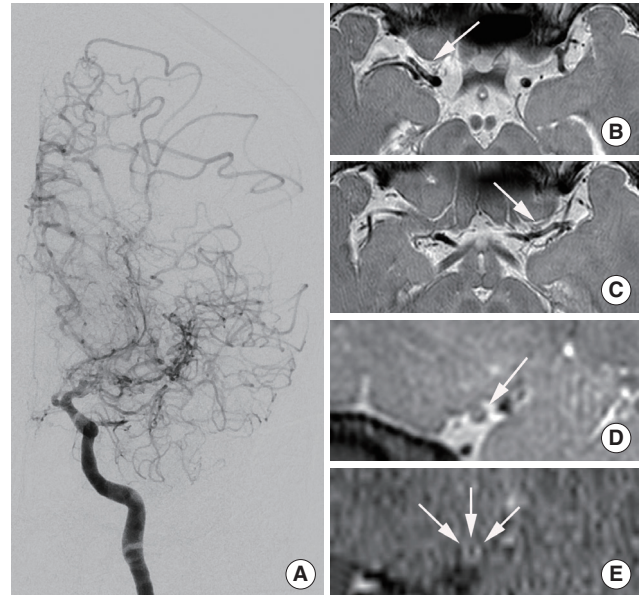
Moyamoya disease. A 44-year-old male patient presented with abulia. (A) Digital subtraction angiography image showing severe stenosis of the left terminal internal carotid artery and middle cerebral artery with basal collaterals. (B, C) The outer diameters of both middle cerebral arteries (arrows) decreased on proton-density imaging. (D) Left middle cerebral artery (arrow) showing a remodeling index of 0.31 on proton-density imaging with (E) concentric and mild enhancement (arrows) on contrast-enhanced T1-weighted imaging.
